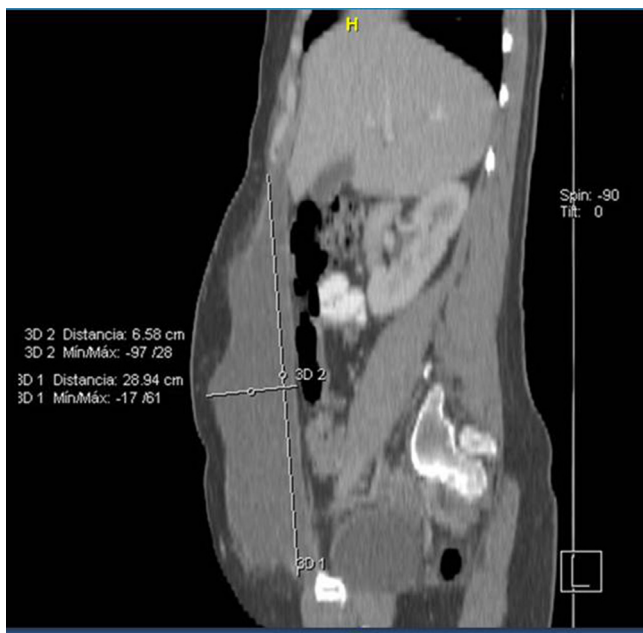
Computed tomography revealed a 1-l periprosthetic seroma.
